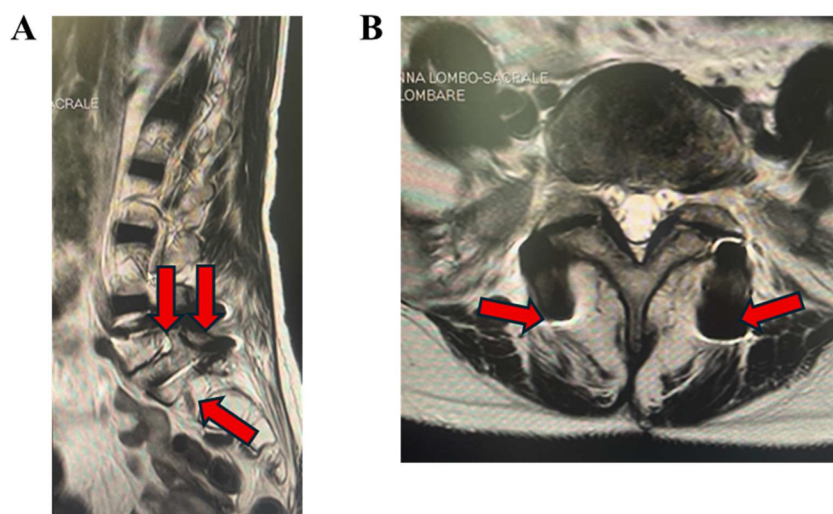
Magnetic resonance imaging (MRI) in multiple planes. (A) Sagittal MRI: Vertebral stabilization at L5–S1 (arrows). (B) Axial MRI: Scan at the L5–S1 disc level showing a mild bilateral median–paramedian protrusion of the annulus, with greater focality in the left intraforaminal region (arrows).
